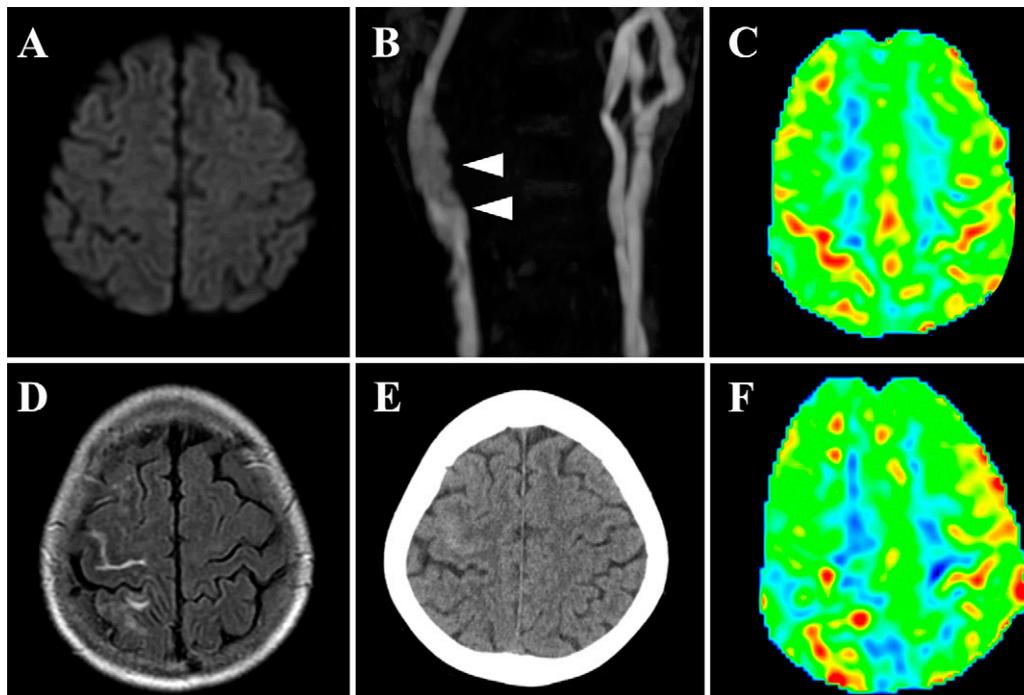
Postoperative imaging. Diffusion-weighted imaging on postoperative day 1 revealed no acute cerebral infarction (A), and the stenotic lesion (*white arrowheads*, B) had improved on MRA. ASL on postoperative day 1 showed no hyperperfusion in the right hemisphere (C). Fluid-attenuated inversion recovery (FLAIR) magnetic resonance imaging (D) and computed tomography (E) on postoperative day 7 showed a thin subarachnoid hemorrhage in the right hemisphere. No global hyperperfusion was observed on ASL on the same day (F).
